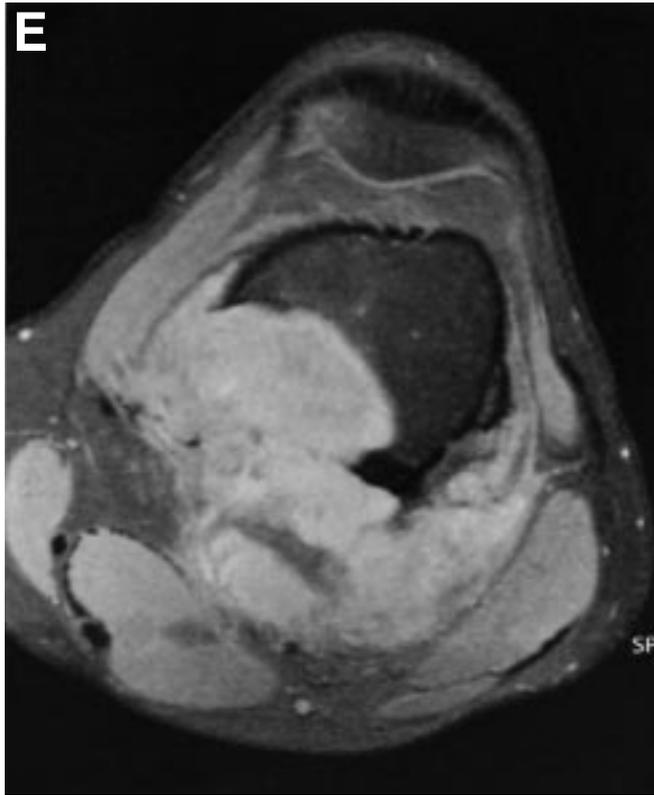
(previous page and left) Preoperative evaluation (local staging) prior to surgery. Preoperative imaging studies are essential to determine the extent of surgical resection and to permit adequate surgical resections with negative margins. Routinely angiography, CT, and MRI are utilized. (A,B) Anteroposterior and lateral angiograms of the distal femoral osteosarcoma following induction treatment. Note that there is minimal vascularity to the tumor that indicates a good tumor response; that is, a high percentage of tumor necrosis. The popliteal artery is displaced posteriorly and may require a vascular graft depending upon the margins of the adventitia at the time of exploration. (C) Axial CT demonstrating a large posterior component without involvement of the knee joint anteriorly and with some ossification of the tumor on the medial aspect. CT is often utilized with MRI in order to determine the intra- and extraosseous extent of the tumor. (D,E) Coronal and axial MRI views of the same tumor. The coronal view shows the soft-tissue extent and the proximal extent within the marrow. The axial view shows the tumor extent posteriorly that corresponds well with the CT. The MRI is the most reliable study to determine intraosseous extension that will permit accurate osteotomy of the femur. CAT scans and MRIs are considered complementary examinations when evaluating bony tumors. Additional information is often obtained from each study.
